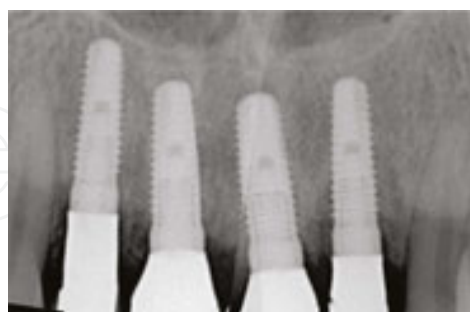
Post-therapy radiographs show that the region is continuing to recover.
